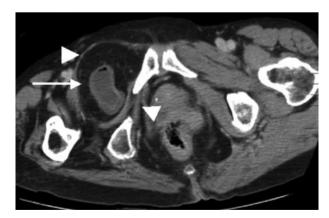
The preoperative CT scan image of patient 3 revealed right obturator hernia containing an incarcerated segment of intestine (arrow), tear of the external and internal obturator muscle and pectineus muscle on the right side (arrow head), as compared with intact ones on the left side.
